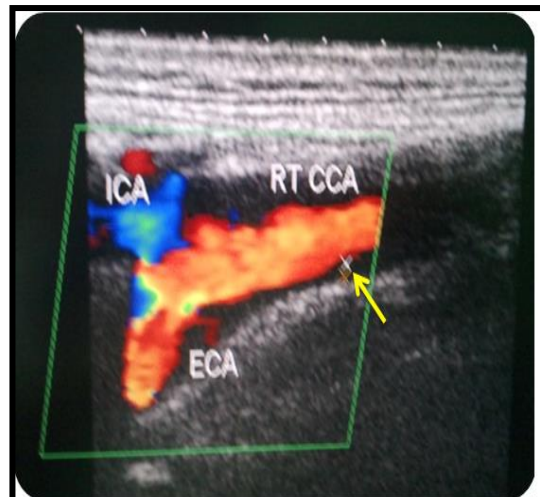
ultrasonic Doppler study of right common Carotid Artery(RTCCA) intima-media thickness.
